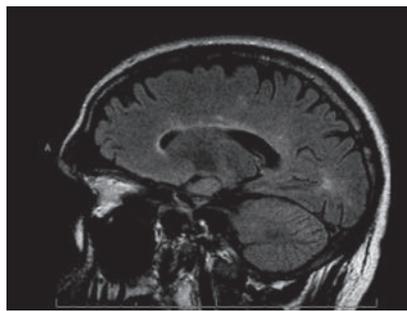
Sagittal T2-weighted FLAIR MRI on second presentation with areas of hyperintense "spoke" lesions along the roof of the corpus callosum, typical of Susac's syndrome.
